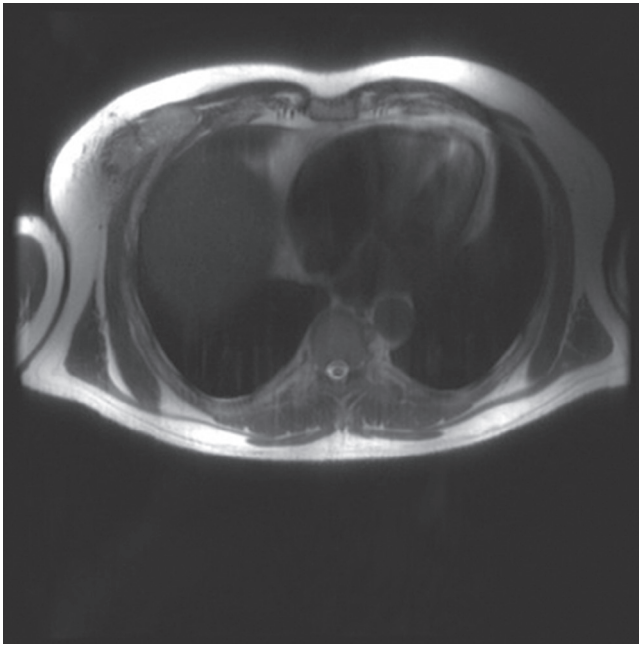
■ MRI of the right anterior chest wall mass seen in Figure 25-1. The MRI is often a better way to delineate the tumor from surrounding tissue.
